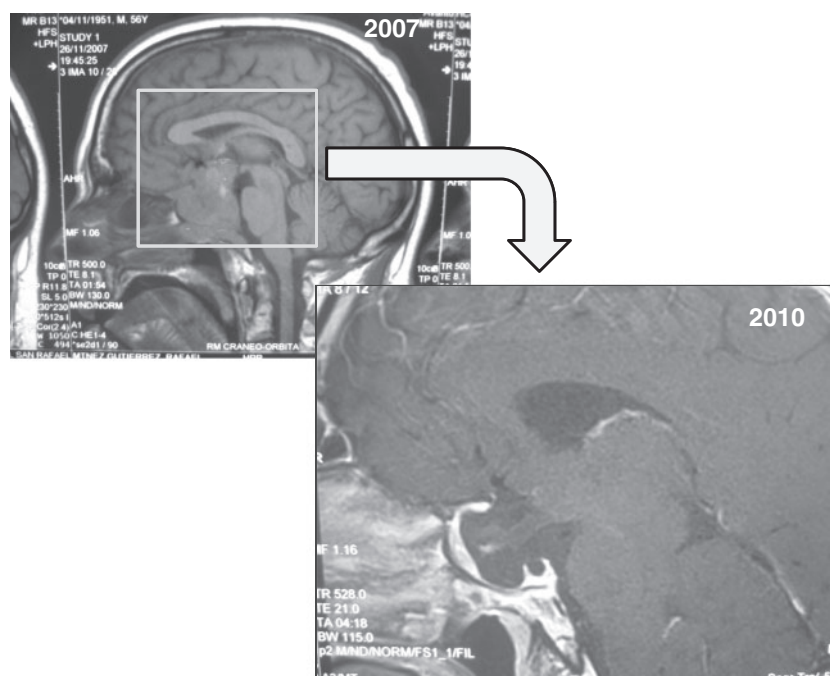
MRI sagittal section that shows the morphological evolution of a macroprolactinoma in a male patient after 3 years of treatment with DA.
